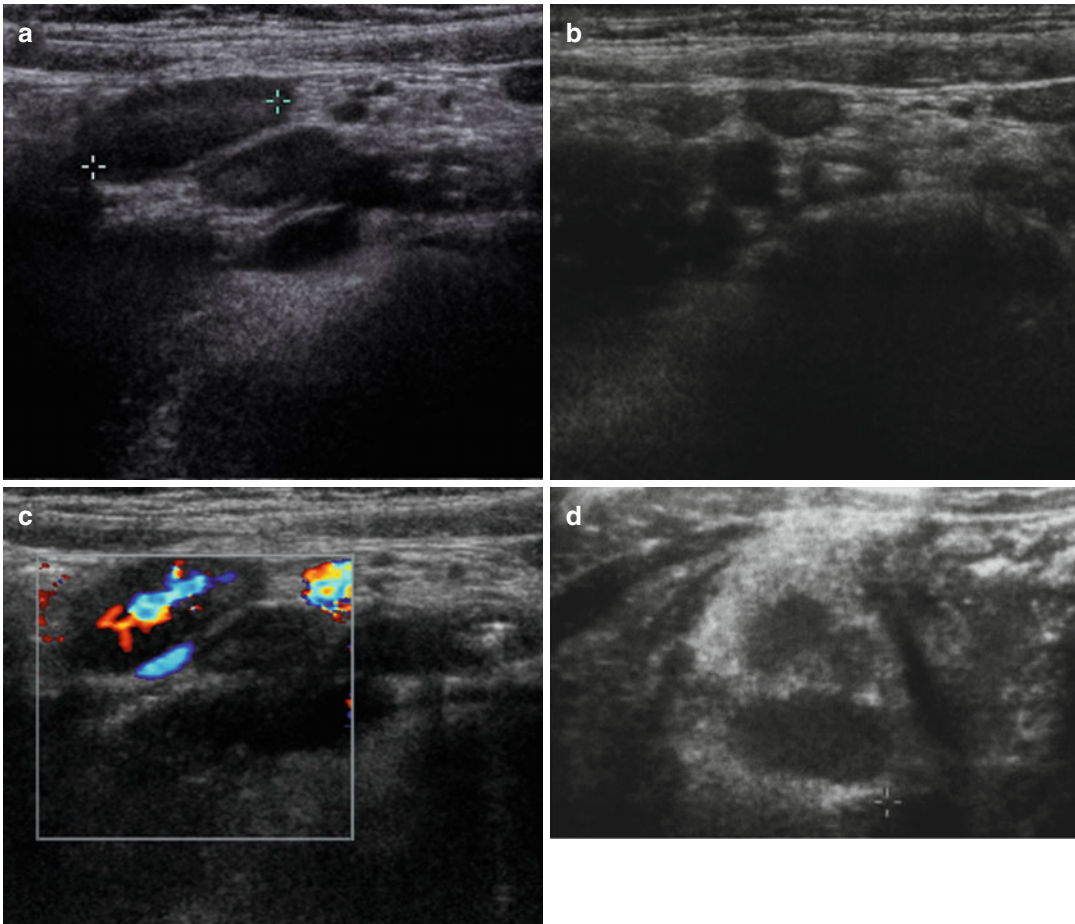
Ultrasonographic findings of appendicitis, such as increased periappendiceal echogenicity that represents fat infiltration (a) and enlarged mesenteric lymph nodes (a–d)
